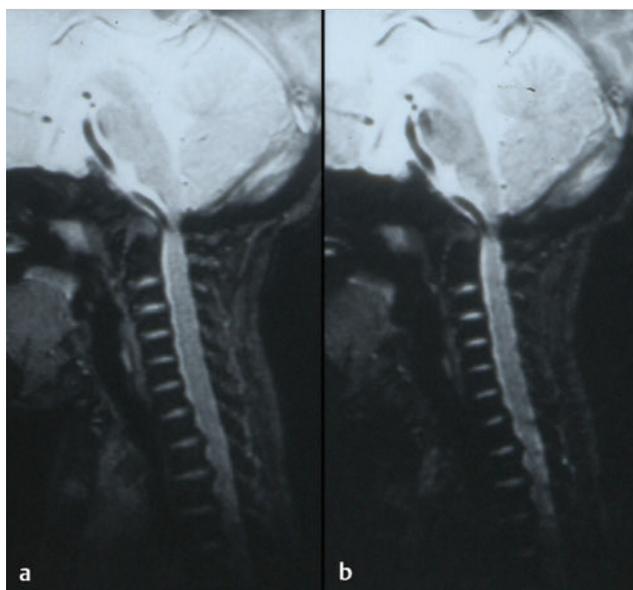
(a) Sagittal T2-weighted magnetic resonance images showing a lack of cerebrospinal fluid flow anteriorly or posteriorly at the level of the foramen magnum. (b) The cervical canal also shows signs of congenital stenosis and a loss of normal lordosis.
